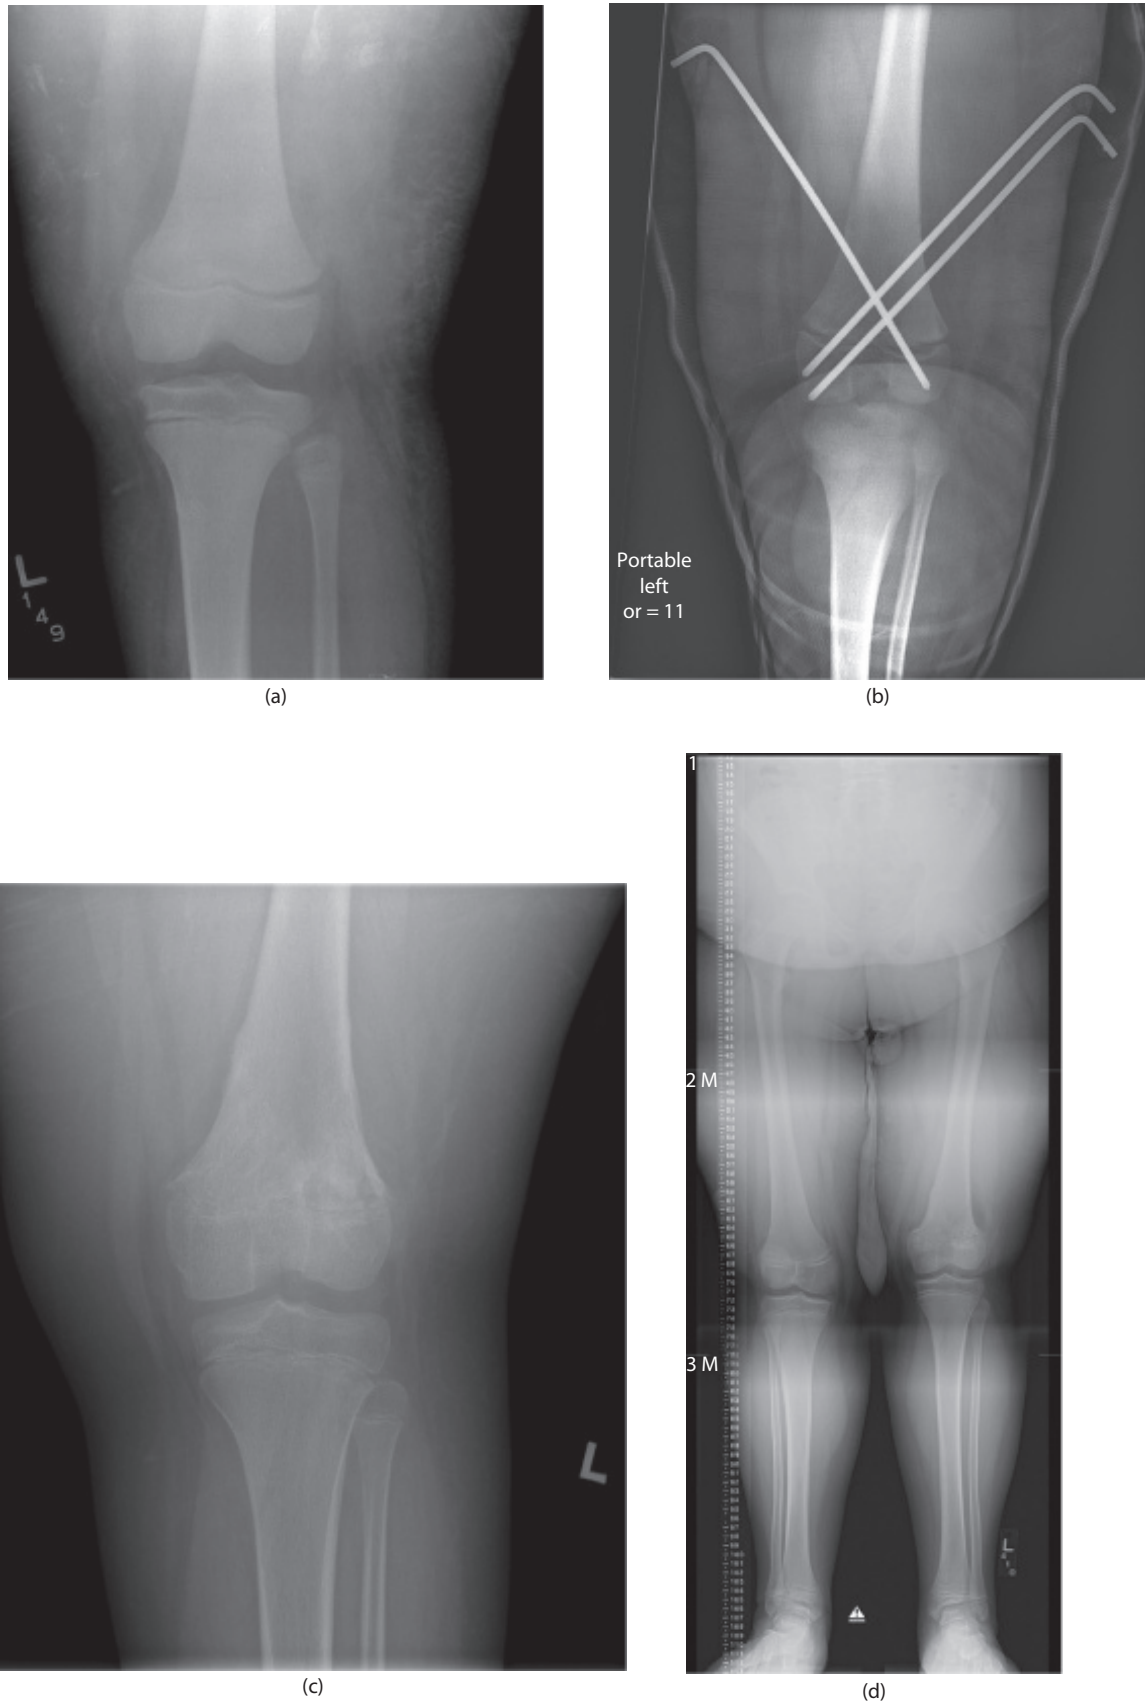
(a) and (b) Radiographs of a 9-year-old male who sustained a Salter-Harris II distal femur fracture with a very small Thurston-Holland fragment that was treated with closed reduction and pinning. (c) and (d) Radiographs at 1 year after injury showed that he had developed premature physeal closure resulting in a leg length discrepancy.
